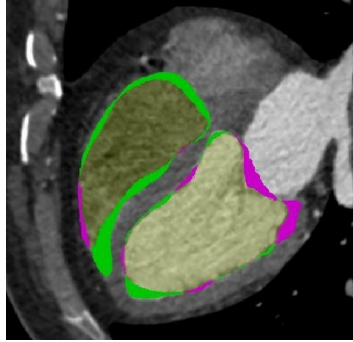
LV and RV differences; difference between transformed LV and RV, and the intra-procedural CT is shown in green color, while difference between transformed LV and RV, and the pre-procedural echocardiography is shown in pink.
